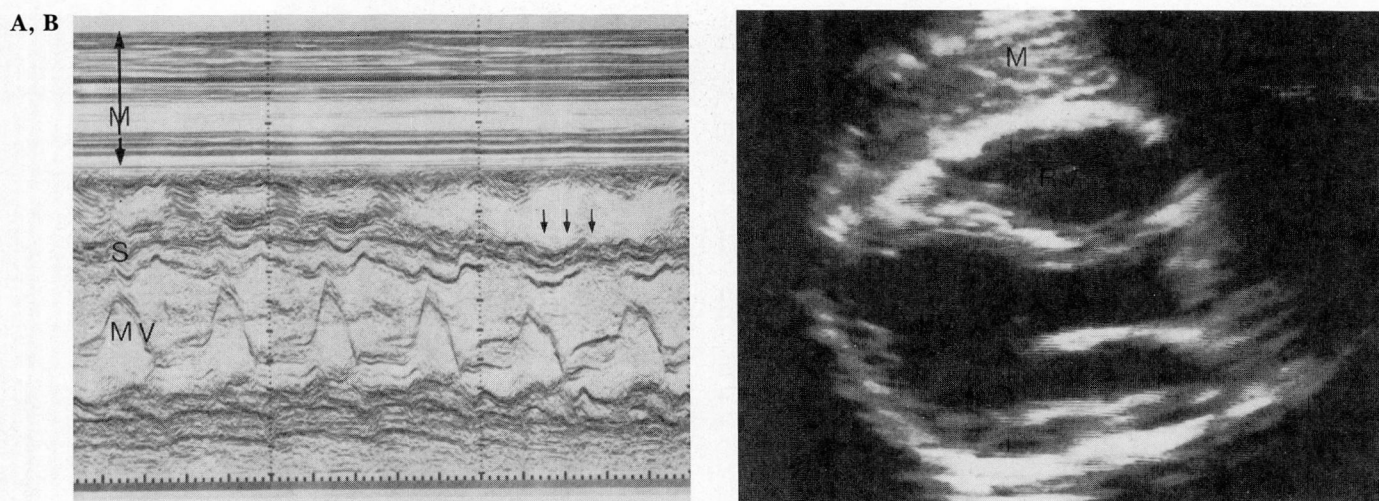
A. M-mode echocardiogram at the level of the mitral valve obtained on admission. There is a tissue density anterior to the heart. Septum shows downward motion during inspiration, resulting in reduction of the left ventricular dimensions. *M* = mass and chest wall, *MV* = mitral valve, and *S* = septum.
